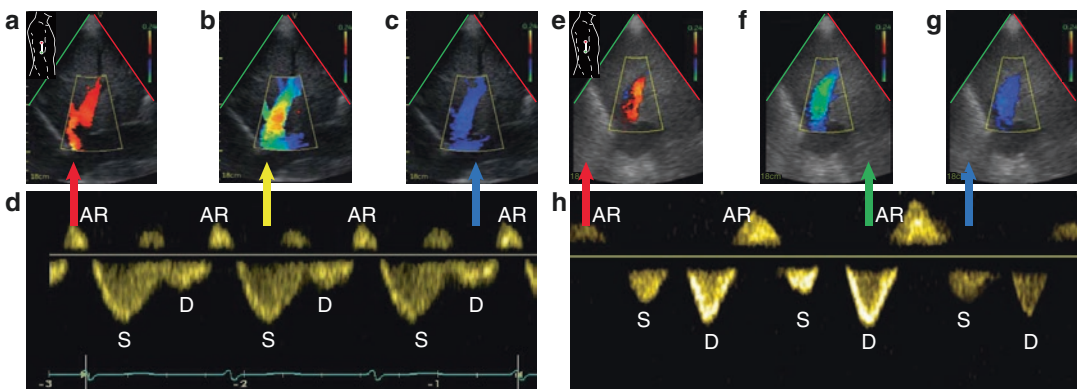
Examination of hepatic venous flow. Triphasic Doppler hepatic venous flow obtained from a subxyphoid abdominal ultrasound image with color (a–c) and pulsed-wave Doppler (d) has an atrial reversal (AR) in red, a systolic (S) phase in blue/green which can be followed by a
